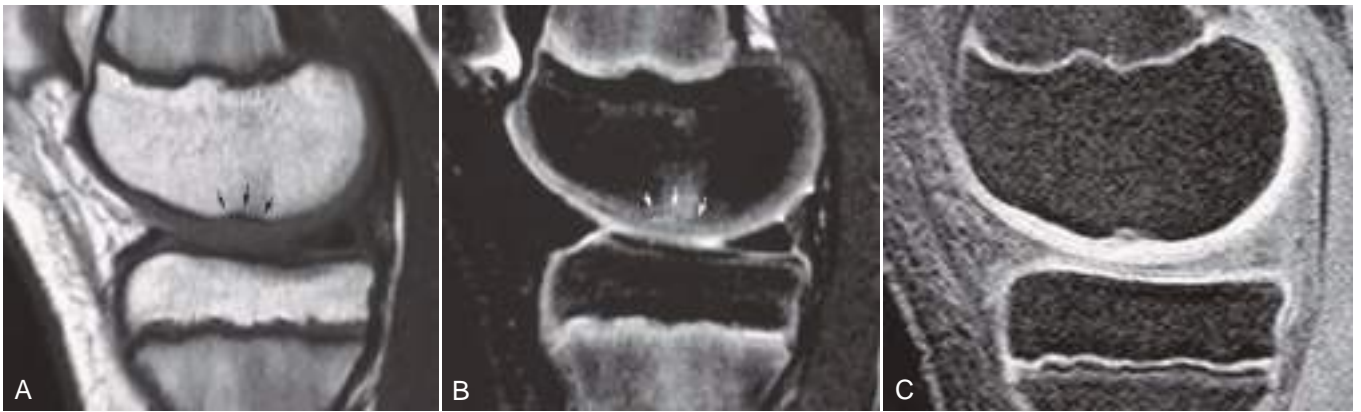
Early osteochondritis dissecans with intact overlying articular cartilage. Sagittal T1-weighted (A), fat-suppressed T2-weighted (B), and sagittal fat-suppressed spoiled gradient-echo MR images (C) show subchondral irregular low-signal line (small arrows) with adjacent marrow edema. Note intact overlying articular cartilage, best seen in C, with normal signal intensity. This could be a subchondral impaction fracture along with early osteochondritis dissecans.
